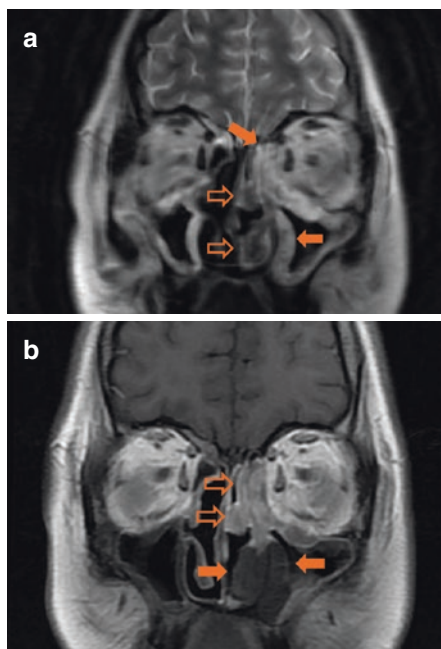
Coronal plane MRI through the mid-orbit without (a, T2 weighted) and with (b, T1 weighted) contrast taken from the same patient demonstrated in Fig. 12.2 with left-sided ROCM pre-endoscopic ethmoidectomy. (a): There is left-sided ethmoid and maxillary sinus mucosal thickening (*closed arrows*) with associated inferior and middle turbinate enlargement (*open arrows*). (b): Contrast-enhanced scan demonstrates enhancing thickened mucosa (*open arrows*) directly adjacent to hypointense ischemic mucosa (*closed arrows*) which is consistent with fungal vascular invasion
